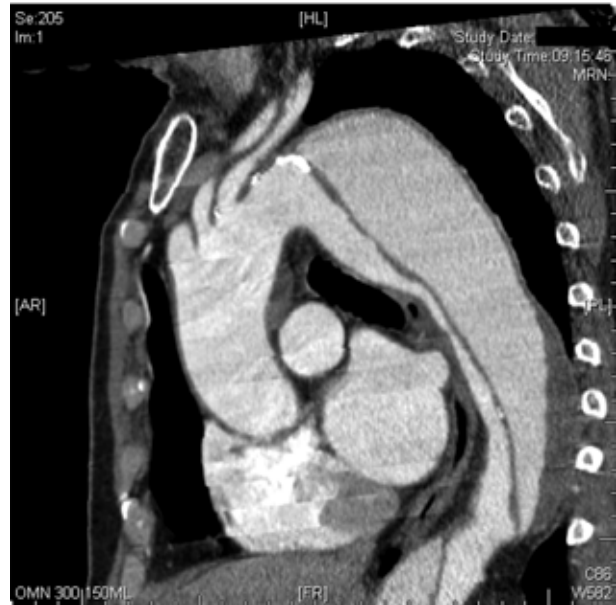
CT showing dissection of the descending thoracic aorta.
